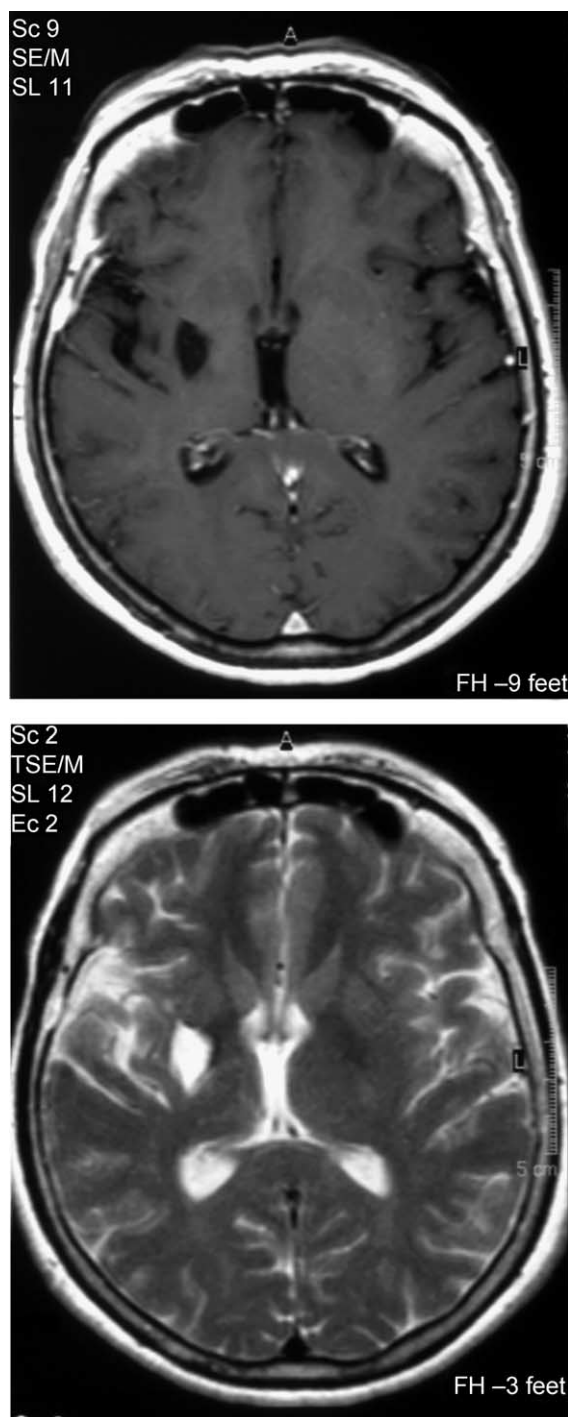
Brain MRI of the patient. The lesion is visible as hypodense and hyperdense area on T1 and T2 weighted images, respectively, involving the posterior part of the right putamen and the globus pallidus.
